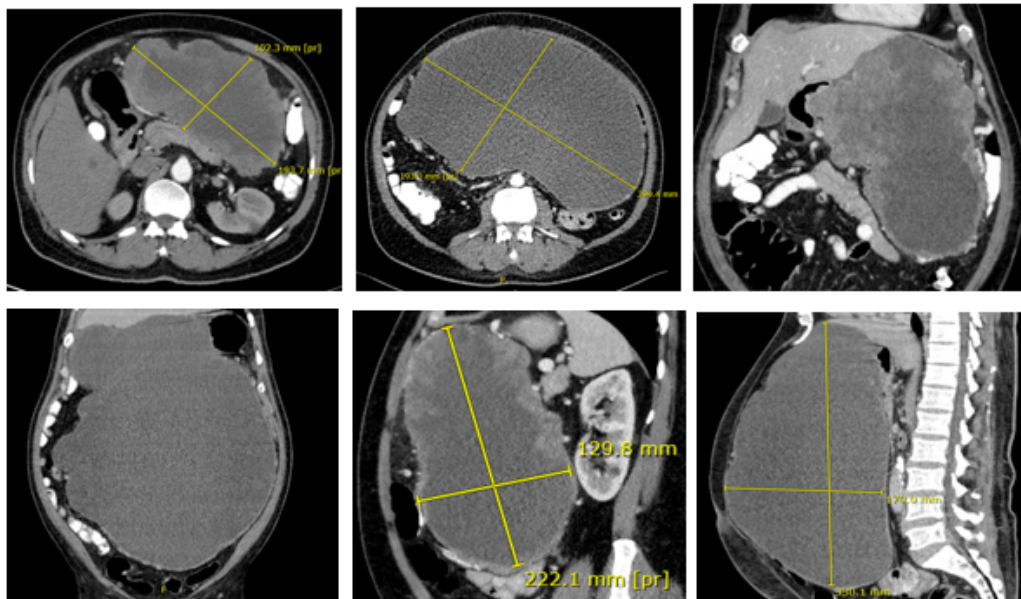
CT comparison between pre and post Imatinib treatment 3 months interval.
